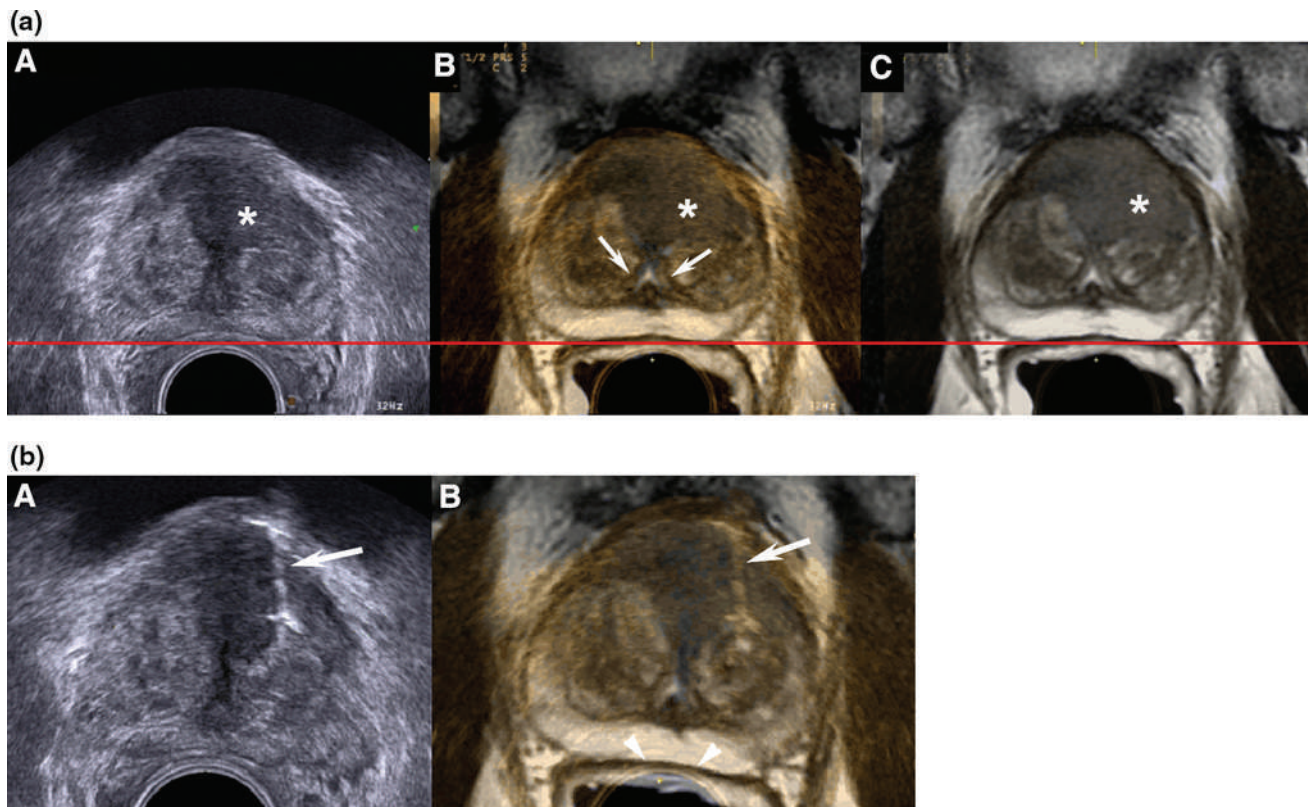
Sensor-based registration. 66-Year-old patient with an elevated PSA level (12 ng/mL). No previous biopsy. a planning phase of the biopsy (A–C). The pair landmark for registration is the veru-montanum, well visible on both modalities (*arrow*). Suspicious area on MRI in the anterior part of the TZ (*), retrospectively detectable on TRUS. The position
